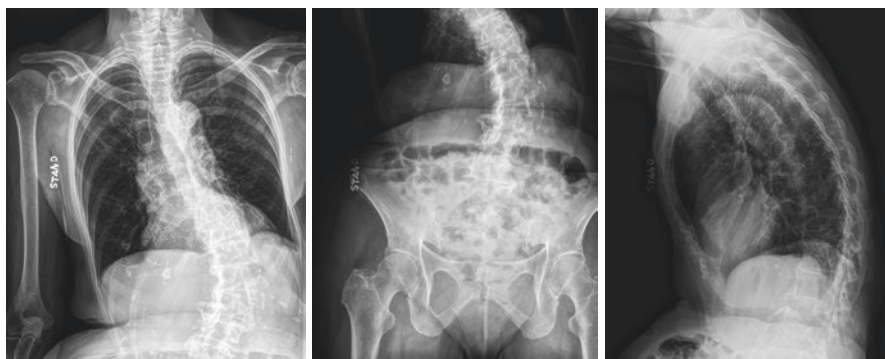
Spinal radiographs of a patient with flank and back pain and unsteady gait. Hyperkyphosis and kyphoscoliosis contribute to iliocostal impingement.
